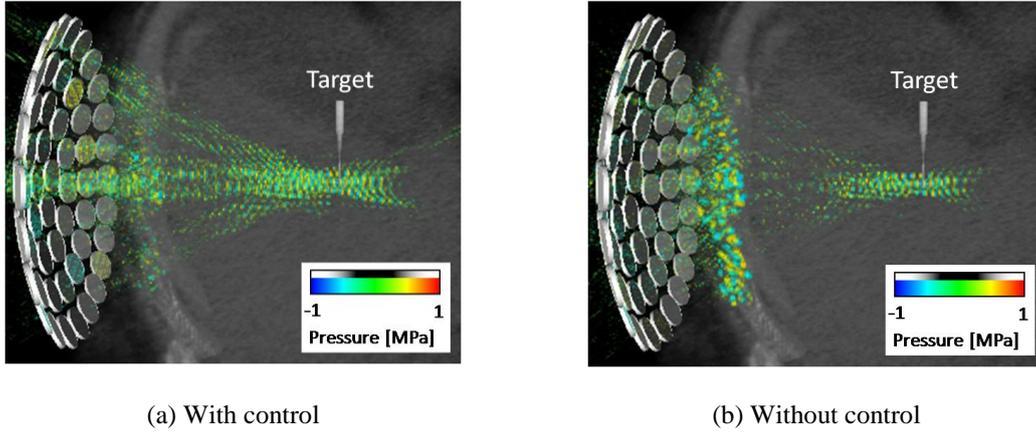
Instantaneous ultrasound fields with and without control of the array transducer in the HIFU therapy for the liver cancer through ribs.
